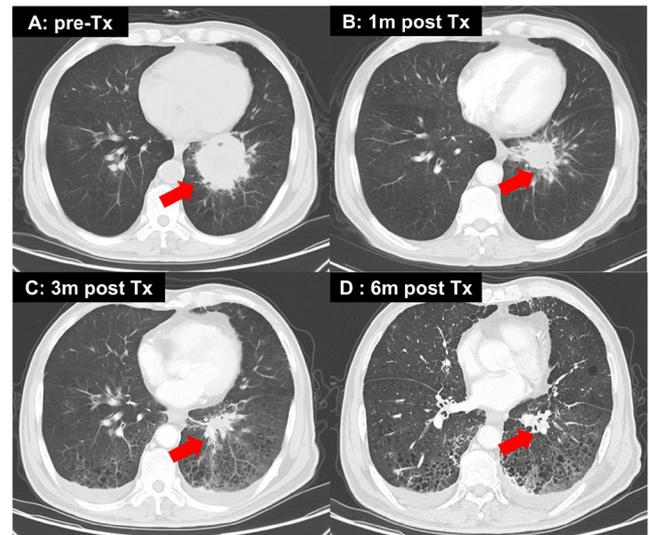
CT scans of the patient showing a left lower lobe nodule (A) prior to treatment with osimertinib and gumarontinib and at (B) one month, (C) 3 months and (D) 6 months follow-up. CT imaging indicated a partial response according to the Response Evaluation Criteria In Solid Tumors.
